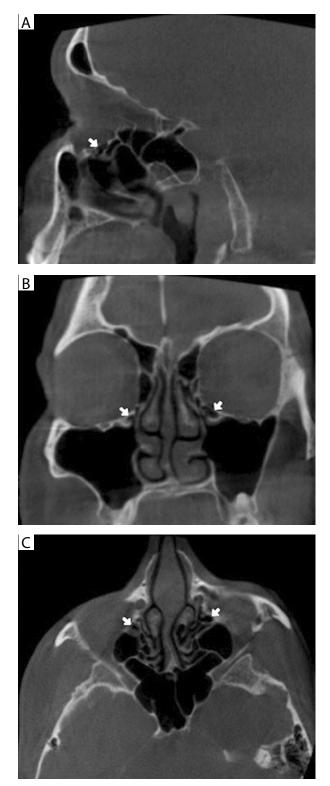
Coronal (A), sagittal (B), and axial (C) conebeam computed tomography images showing Haller cell (white arrows)
